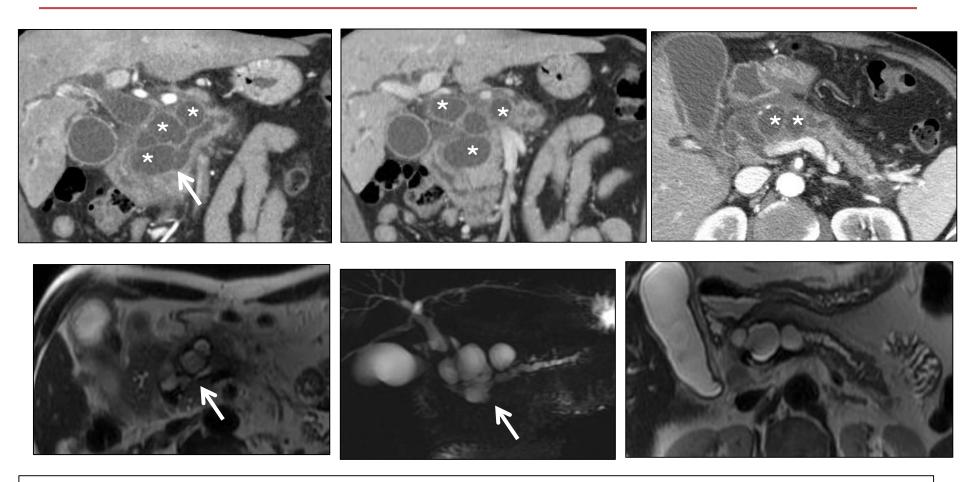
Patient 2. Contrast enhanced CT, MR T2 axial and Colangio-MR images. Multiples cystic lesions (*) on the head and neck of the pancreas and mild dilatation of MPD until the uncinate process (arrow), where there is an stenosis. There was no clear connection between the cystic lesions and the MPD, there was no clear mass at the point of MPD stenosis. Differential diagnosis was intraductal papillary mucinous tumor versus pancreatic pseudocyst. Endoscopic ultrasound was recommended.
